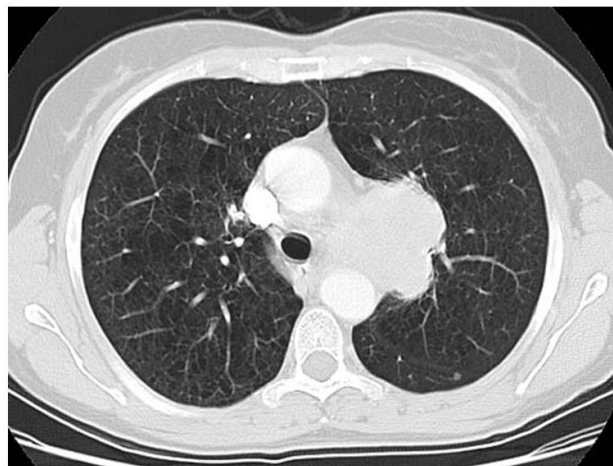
Physiological chest CT [e].
